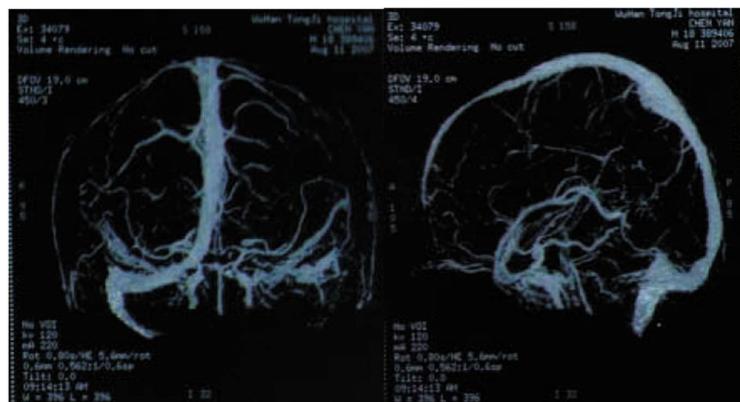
MRI 见左侧横窦大静脉不显影,右侧横窦、上矢状窦、脑表面静脉明显代偿扩张
